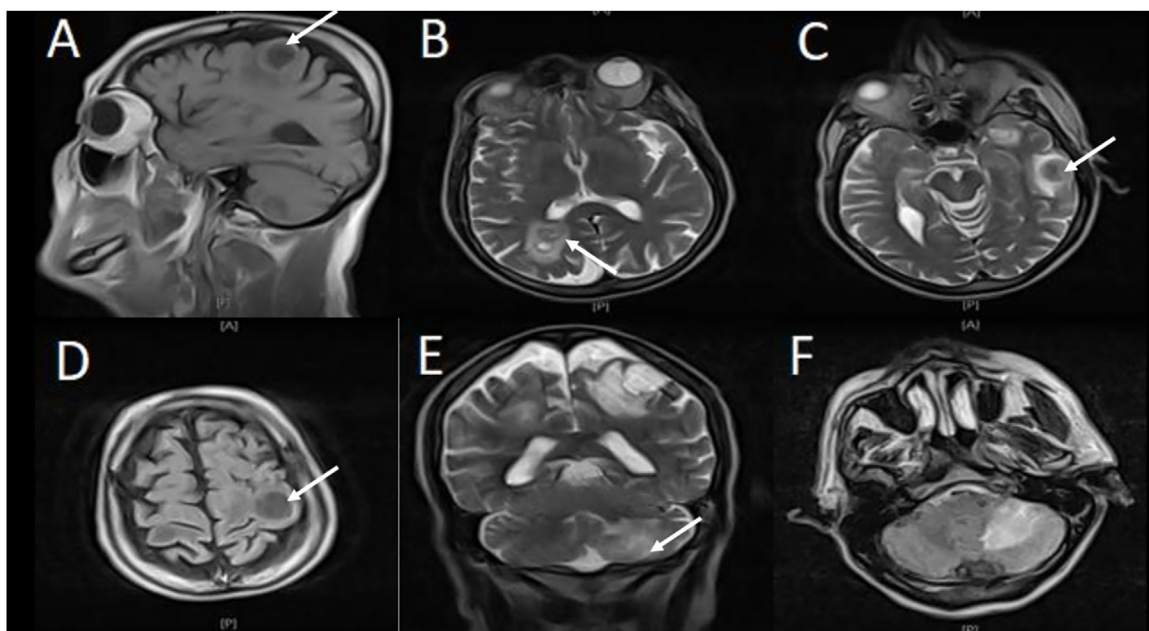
MRI brain without gadolinium showing multiple brain lesions. (A) sagittal T1. (B)(C) axial T2. (D) axial T1. (E) coronal T2. (F) axial T1.
